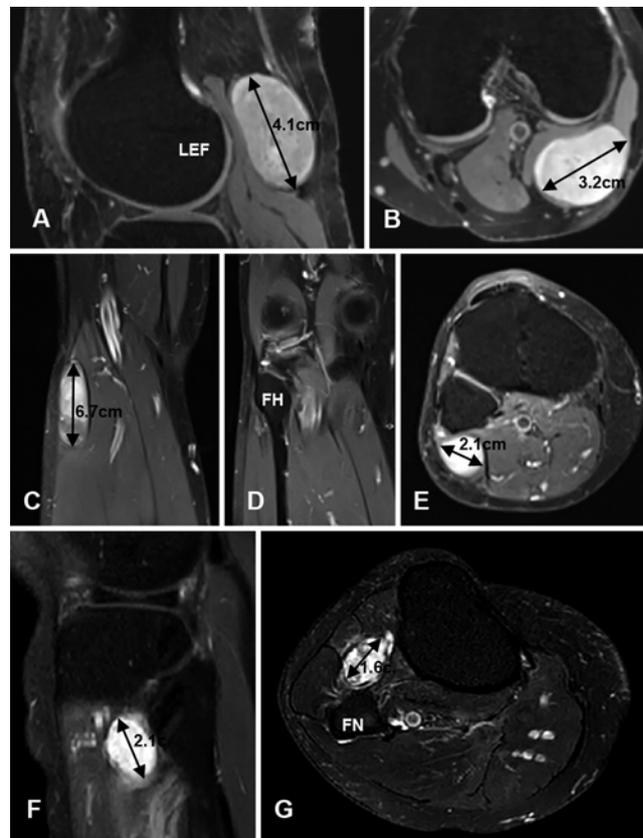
T1-weighted Gd-enhanced MR images of CPN schwannomas at the three levels investigated in our surgical series. Sagittal (A) and axial (B) images of a case of a large CPN schwannoma proximal to the FH, at the level of the lateral epicondyle of the femur. Coronal (C and D) and axial (E) images obtained in a case of a large CPN schwannoma at the FH. Sagittal (F) and axial (G) images of a relatively smaller CPN schwannoma in the articular branch at the level of the fibular neck.
